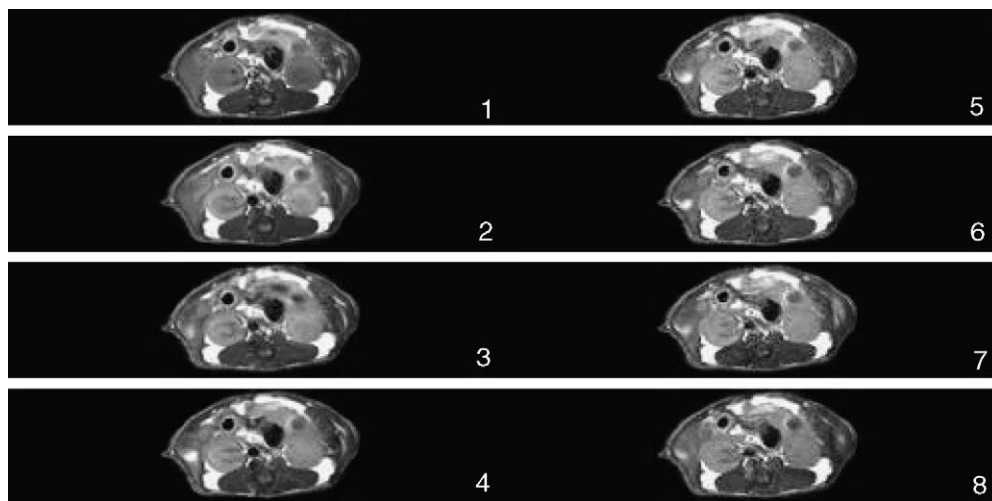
Representative in vivo MR images focusing on a cross-section containing kidneys. Pictures marked by 1 is the image before administration, while those marked by numbers 2–8 correspond to the images taken at 0, 9, 18, 27, 35, 44 and 52 min after administration of $\text{Gd@C}_{82}(\text{OH})_{22}$.
